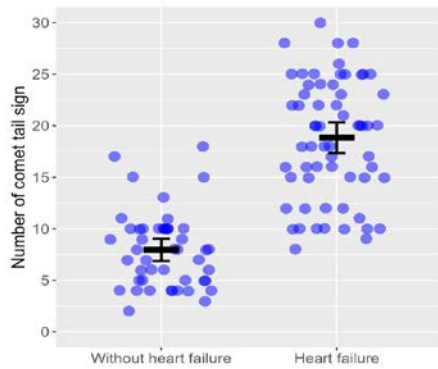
Number of ultrasound lung “comets” in relation to the presence/absence of heart failure.
